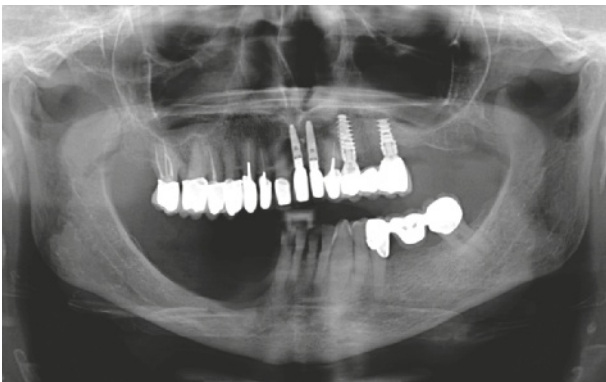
Panoramic radiograph of the defect.
